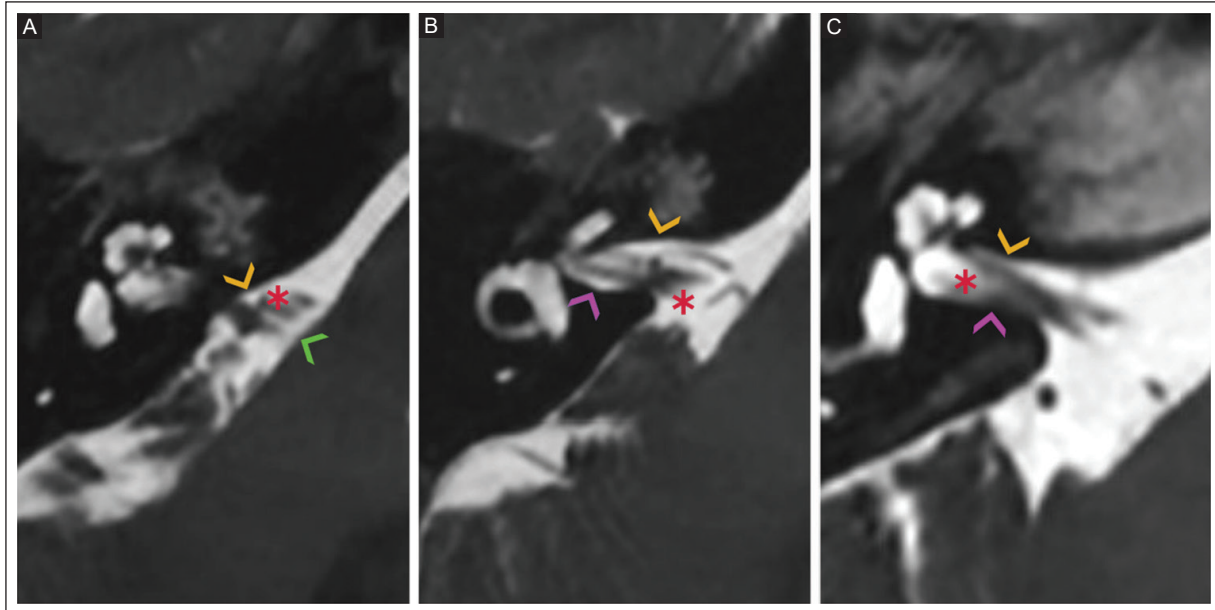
A 3.0T MRI T2- weighted CUBE shows Chavda types of NVC based on the depth of vascular loop extension into the internal auditory canal. A: a 66-year-old man with tinnitus and vertigo. NVC Chavda type I (yellow arrowhead) shows an anterior cerebellar artery loop (asterisk) in the cerebellopontine angle (green arrowhead). B: a 61-year-old woman with hemifacial spasm. NVC Chavda type II (yellow arrowhead) shows an anterior cerebellar artery loop (asterisk) extending into the internal auditory canal (purple arrowhead), but less than 50% of its length. C: a 54-year-old man with hemifacial spasm. The yellow arrowhead shows NVC Chavda type III with an anterior cerebellar artery loop (asterisk) extending more than 50% into the internal auditory canal (purple arrowhead).
